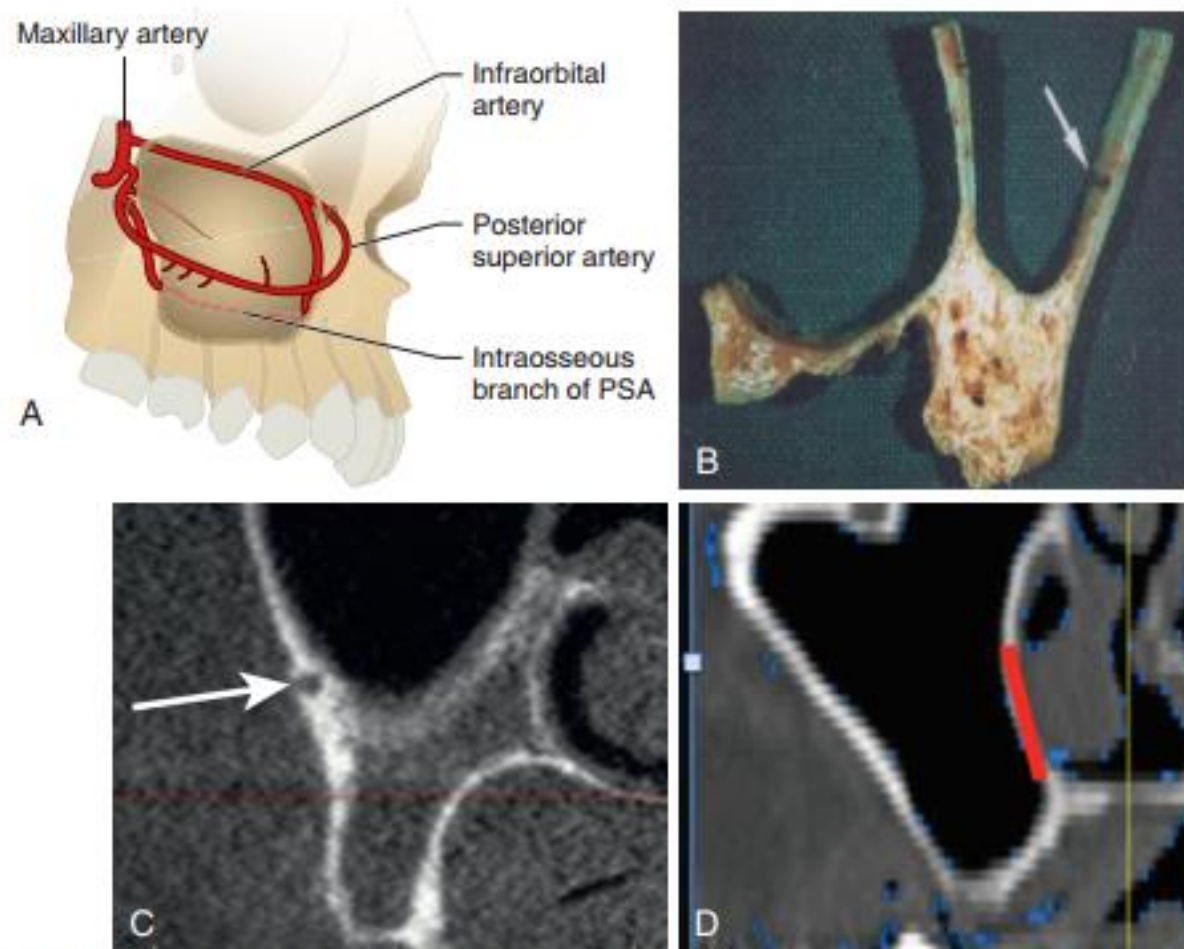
(A) The extra- and intraosseous anastomosis, which is made up of the infraorbital and posteriorsuperior artery. (B) Intraosseous notch (*arrow*) containing the intraosseous anastomosis, which comprises the posterior superior artery and infraorbital artery. (C) Cross-sectional CBCT image depicting intraosseous anastomosis (*arrow*). (D) Posterior lateral nasal artery location in the medial wall of the maxillary sinus.
